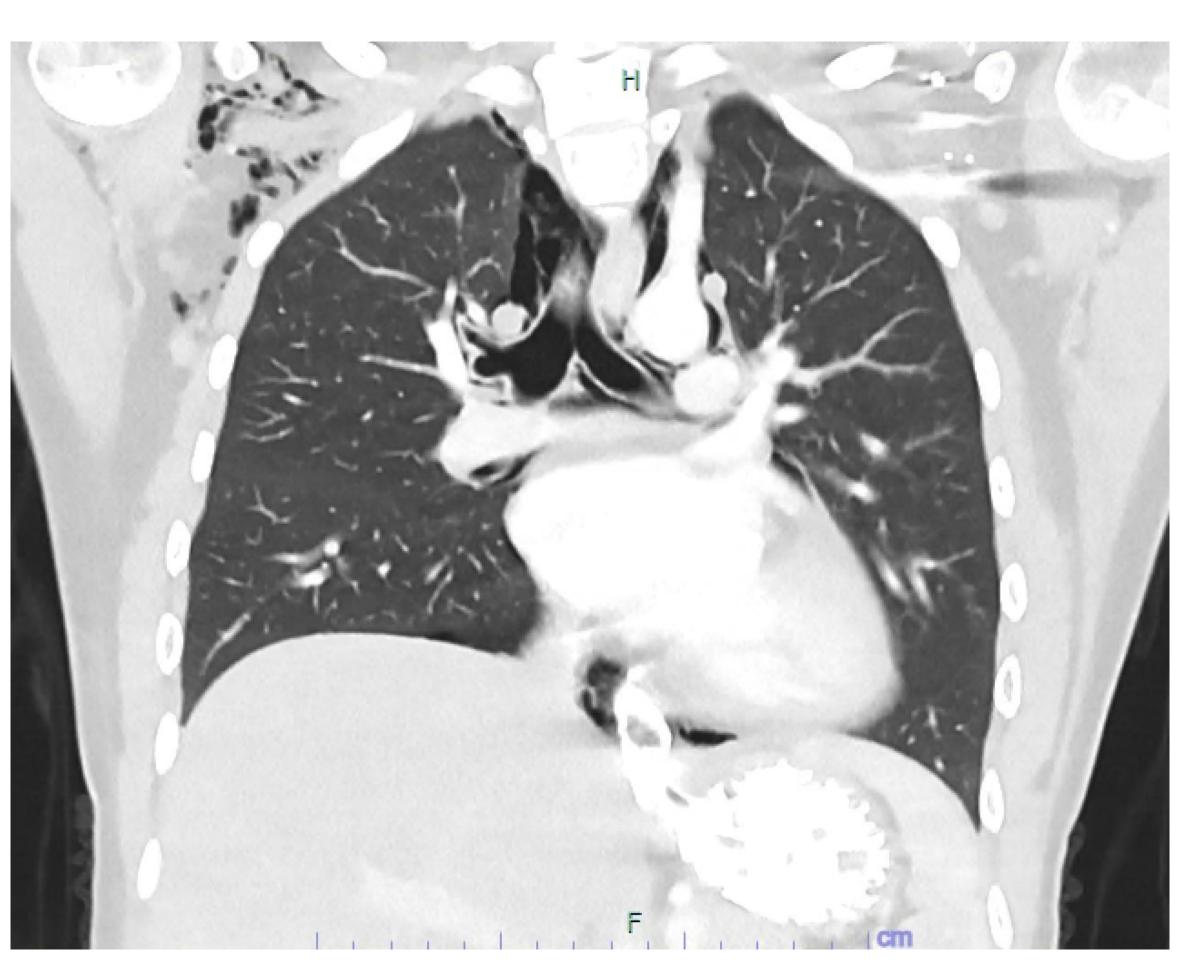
CT CAP with oral contrast, coronal + sagittal sections
